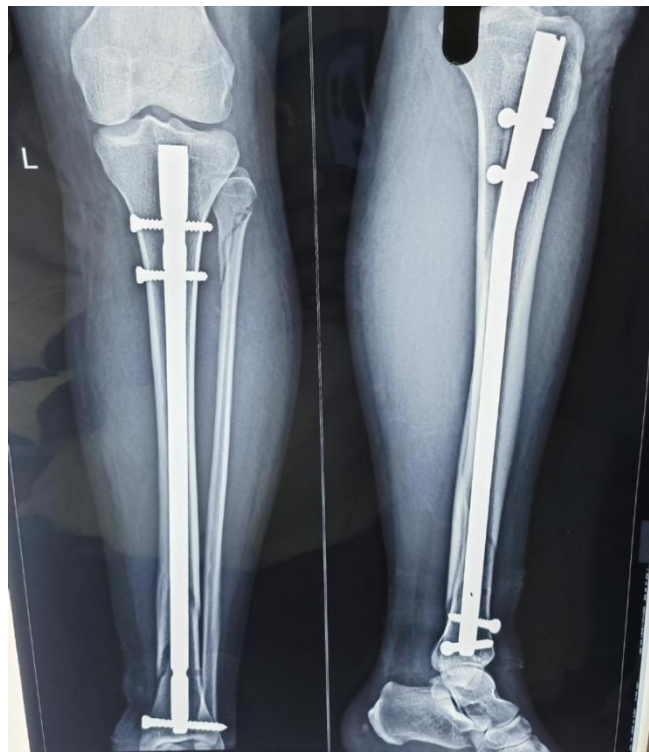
Postoperative day-2 AP and lateral radiographs showing satisfactory alignment of the distal tibial fracture fixed with an intramedullary interlocking nail, two proximal locking screws, and distal anteroposterior and mediolateral locking screws.
